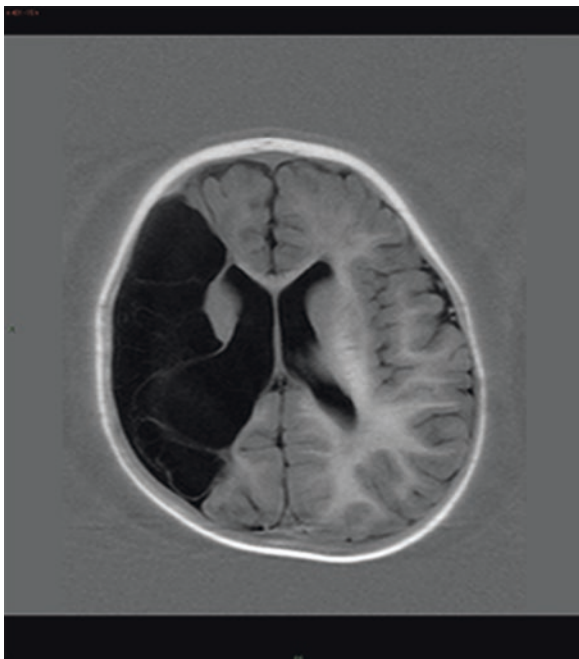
Sequelae of right middle cerebral artery (MCA) territory infarct. Axial T1-weighted MR image shows cystic change in the right MCA territory after a previous infarct. Dilatation of the right lateral ventricle is secondary to the parenchymal loss
